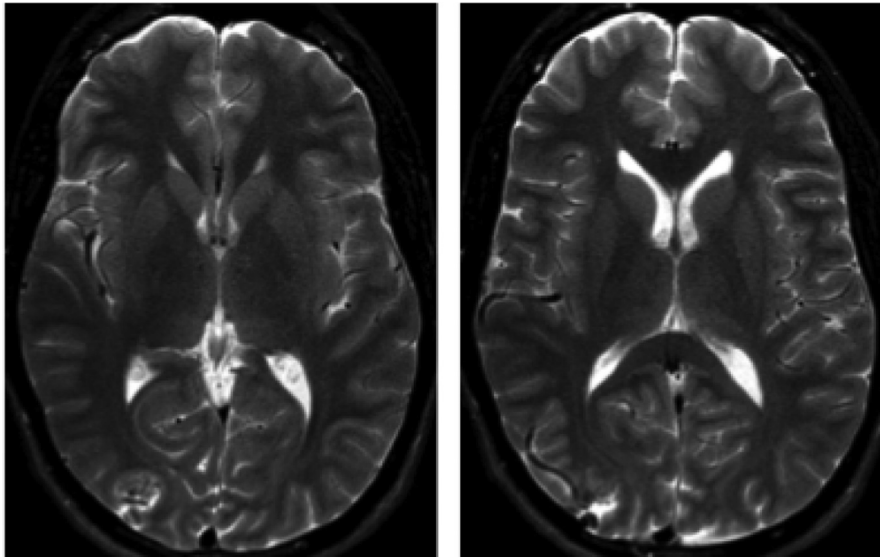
Axial T2-weighted MRI images with right occipital flow voids suggestive of possible intracranial arteriovenous malformation (AVM).
